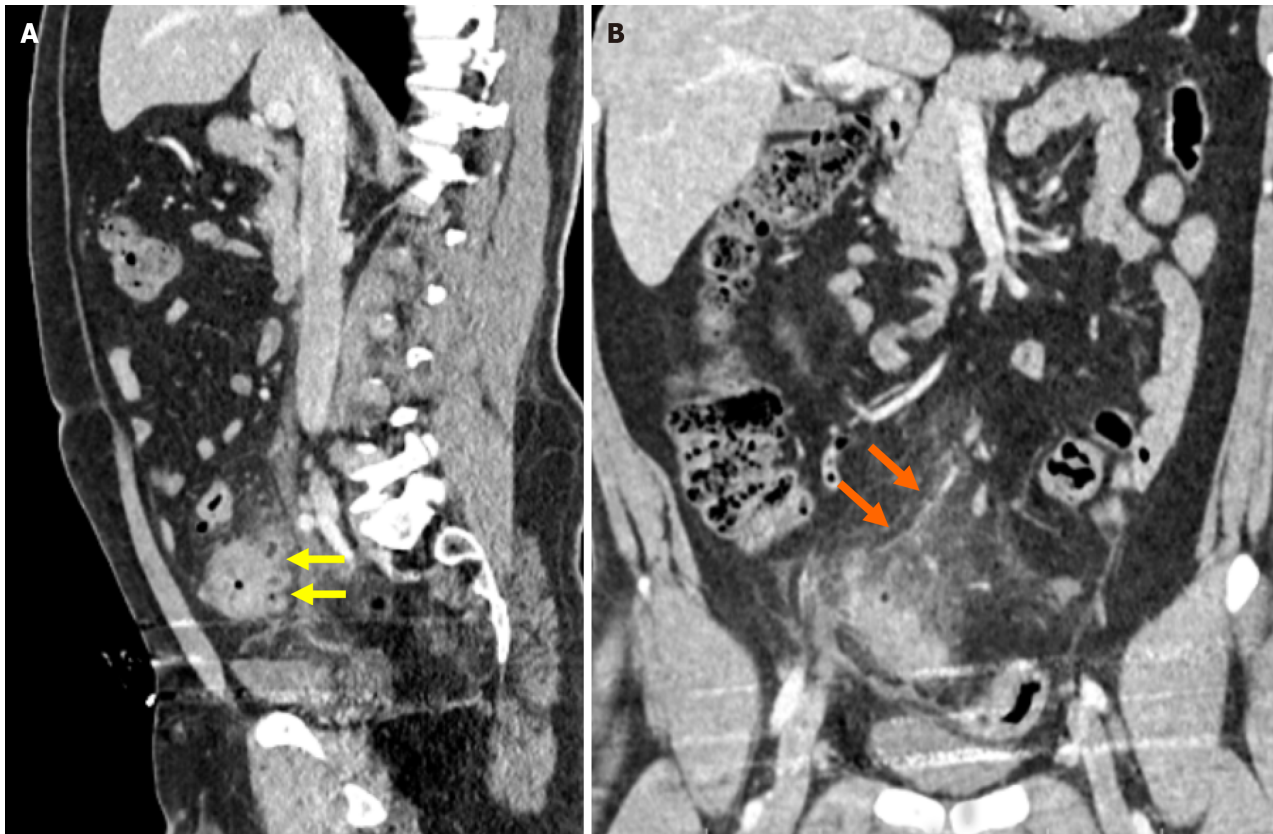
Pylephlebitis secondary to sigmoid colon diverticulitis. A: Contrast-enhanced sagittal reformatted computed tomography (CT) image demonstrated segmental wall thickening of the sigmoid colon, fat stranding in the surrounding mesenteric fat, and the presence of multiple diverticula, consistent with diverticulitis (yellow arrow); B: Contrast-enhanced coronal reformatted CT image showed a dilated venous structure with a lack of contrast enhancement in continuity with the inferior mesenteric vein, suggestive of thrombophlebitis (orange arrow).
